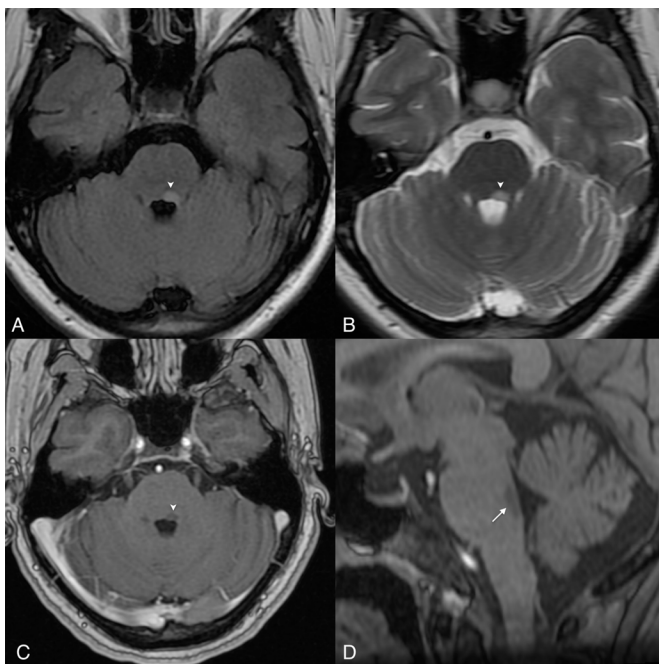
A contrast-enhanced MRI reveals a non-contrast enhancing Fluid-Attenuated Inversion Recovery (FLAIR) and T2 hyperintense (A, B) and T1 hypointense (C, D) lesion on the facial colliculus (arrowheads).
